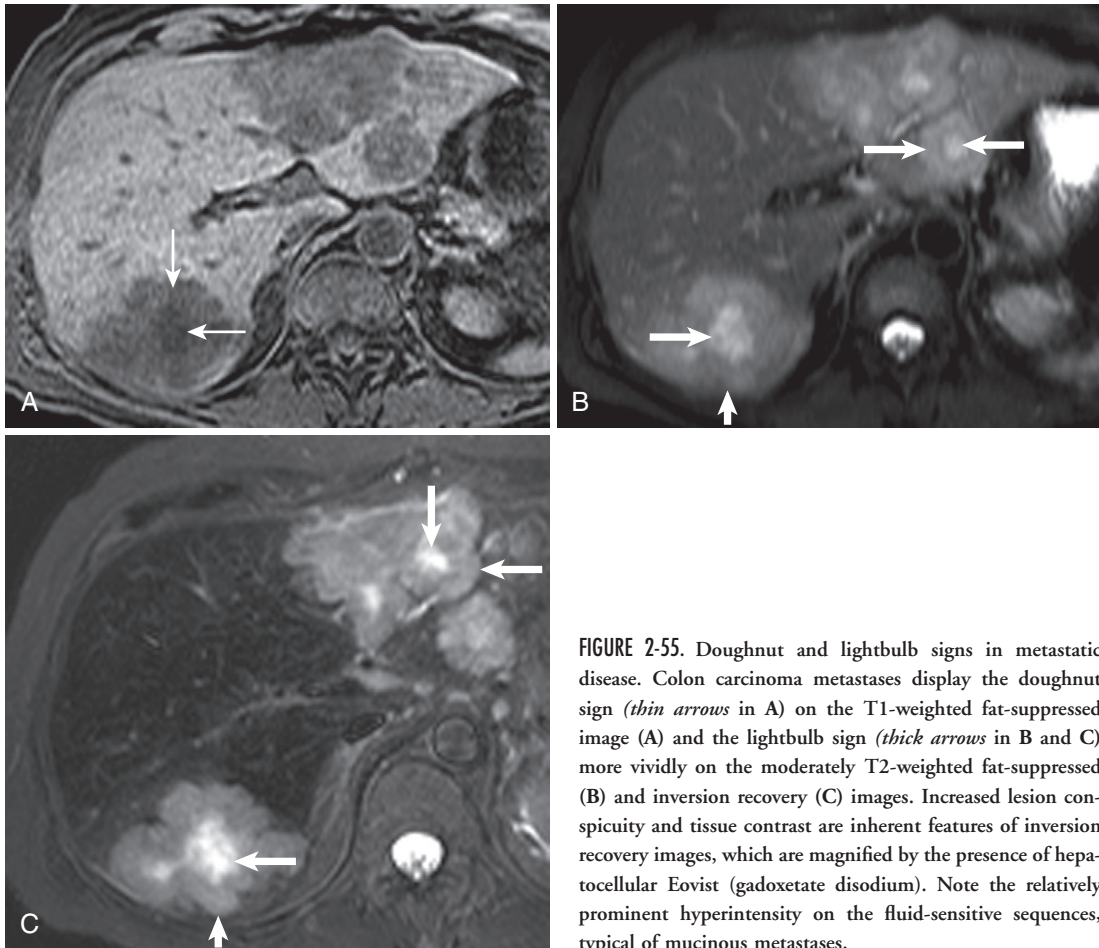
Doughnut and lightbulb signs in metastatic disease. Colon carcinoma metastases display the doughnut sign (*thin arrows* in A) on the T1-weighted fat-suppressed image (A) and the lightbulb sign (*thick arrows* in B and C) more vividly on the moderately T2-weighted fat-suppressed (B) and inversion recovery (C) images. Increased lesion conspicuity and tissue contrast are inherent features of inversion recovery images, which are magnified by the presence of hepatocellular Eovist (gadoxetate disodium). Note the relatively prominent hyperintensity on the fluid-sensitive sequences, typical of mucinous metastases.
